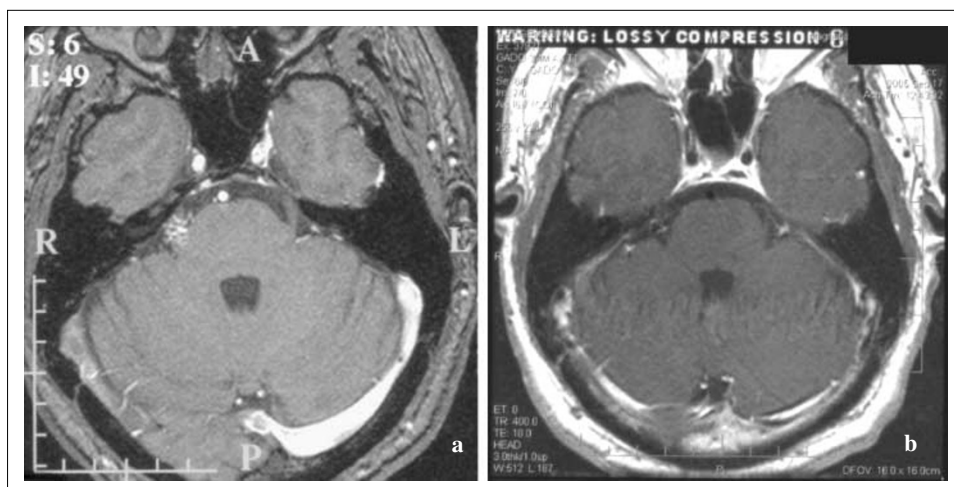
MRA single slice source image through the cerebellopontine region demonstrates the abnormal vasculature in the right CP angle. b Post-treatment T1 axial MRI with gadolinium at the same level showing reduction in size of the lesion (nidus read at 0.8x0.4 cm on this slice)
